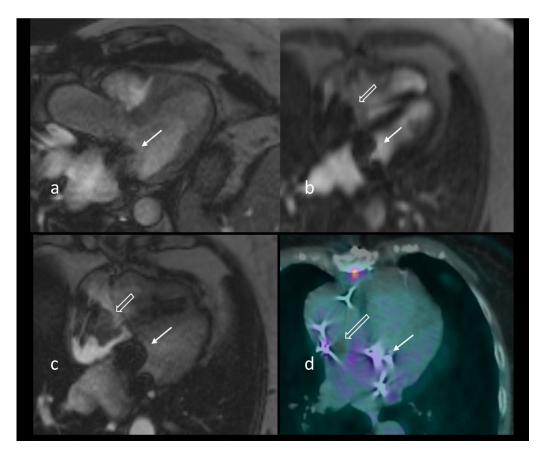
Representative images of the second cardiac MRI 18-month post tumor resection and mitral valve replacement and PET/CT. (A) Three chambers perfusion, (B) Four chambers perfusion, (C) Four chambers GRE, (D) PET/CT scan. Mitral valve replacement (arrow on A-D) with no evidence of local recurrence. There is a clot within the right atrium abutting pacemaker leads (open arrow on B, and C). A focal area of photopenia corresponds to a clot visualized on MRI (open arrow on D).
